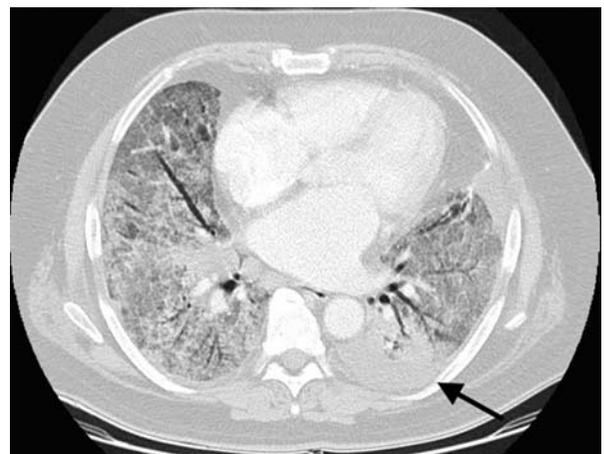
TKI-induced pneumonitis, diffuse alveolar damage pattern. Contrast-enhanced axial CT image shows diffuse ground-glass opacification with dependent dense consolidation (black arrow) in a patient receiving erlotinib.
